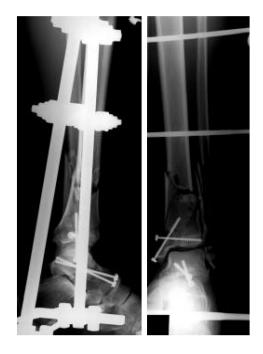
X-Rays after stabilization with external fixator
